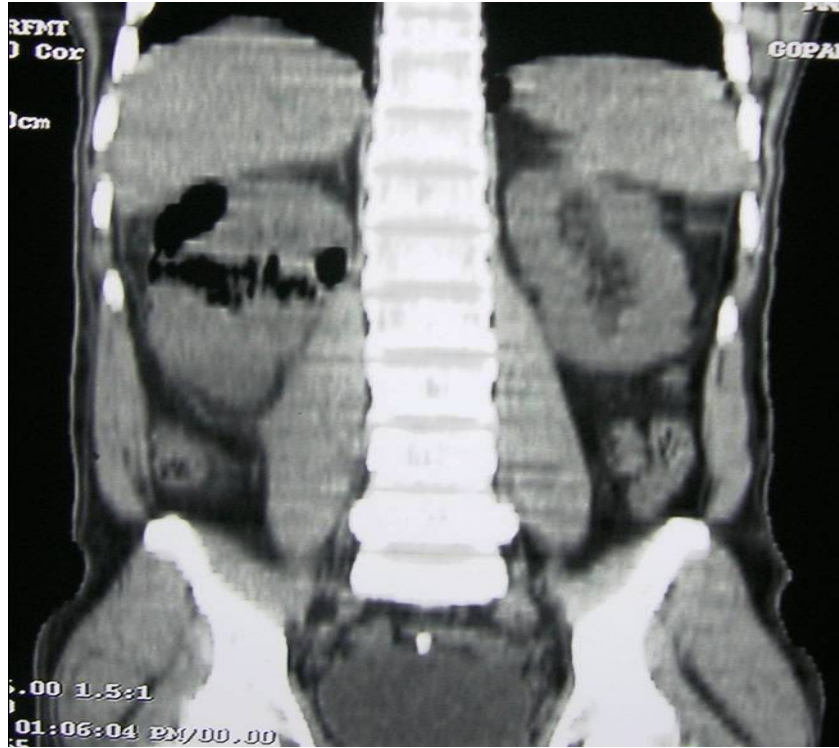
CT KUB Class 2 EPN
